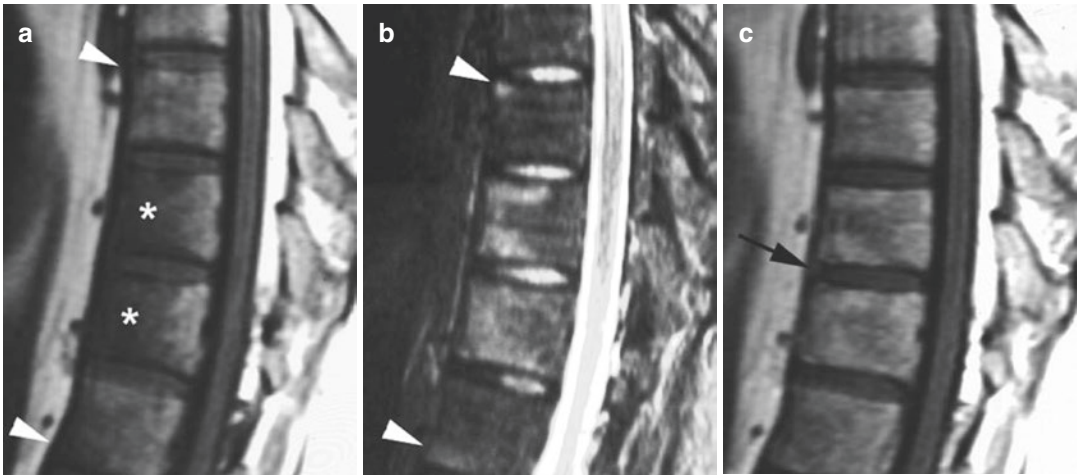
Romanus spondylitis. Sagittal T1-weighted (a), fat-suppressed T2-weighted (b) and gadolinium-enhanced T1-weighted (c) spin echo MR images demonstrate signal intensity changes at the anterior vertebral
